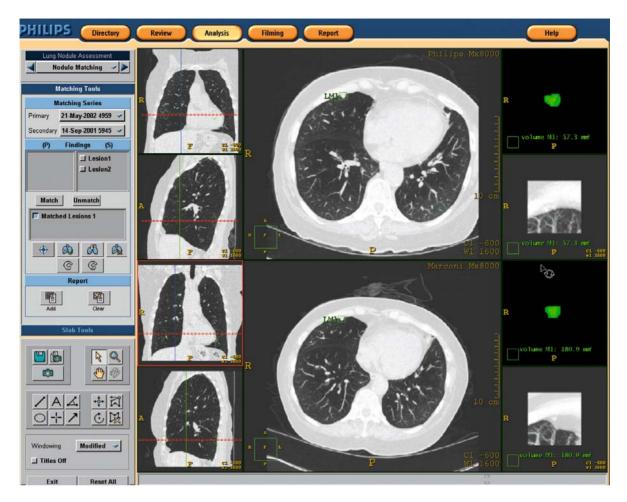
Many manufacturers propose computer-assisted detection (CAD) and nodule segmentation for nodule growth and comparison on serial CT scanners. At baseline CT, the nodule volume was measured at 57 mm³. Then 8 months after, the nodule volume was measured at 180 mm³. The nodule growth was consistent with malignancy
